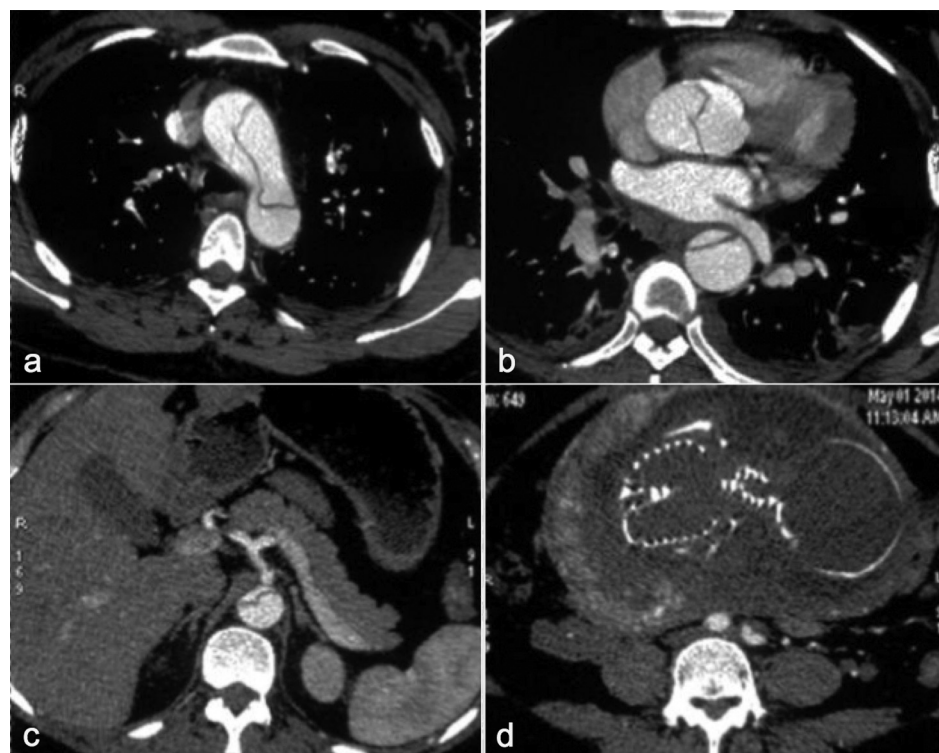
Axial computed tomography images of a 36-year-old woman with acute type A dissection at 26 gestational weeks at the level of the (a) aortic arch, (b) left atrium, (c) celiac trunk, and (d) iliac bifurcation.
